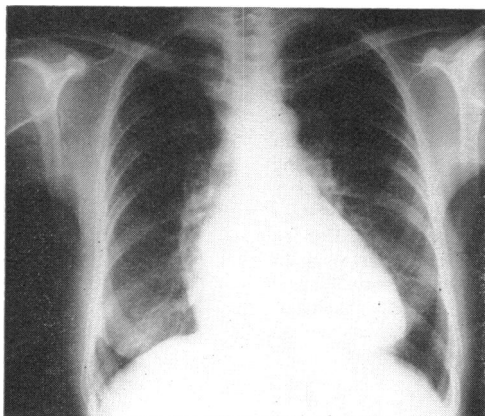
X-ray on readmission, showing further increase in cardiac size.
